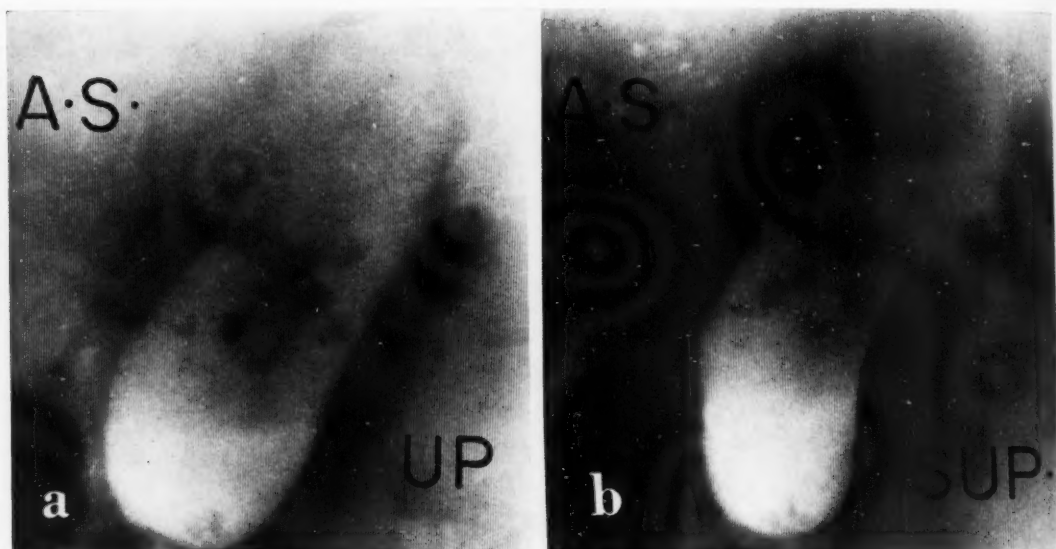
Roentgenograms of the gallbladder before a fat meal in the (a) erect and (b) supine positions. *Note* the multiple defects in the dye-filled lumen, possessing the following characteristics:
